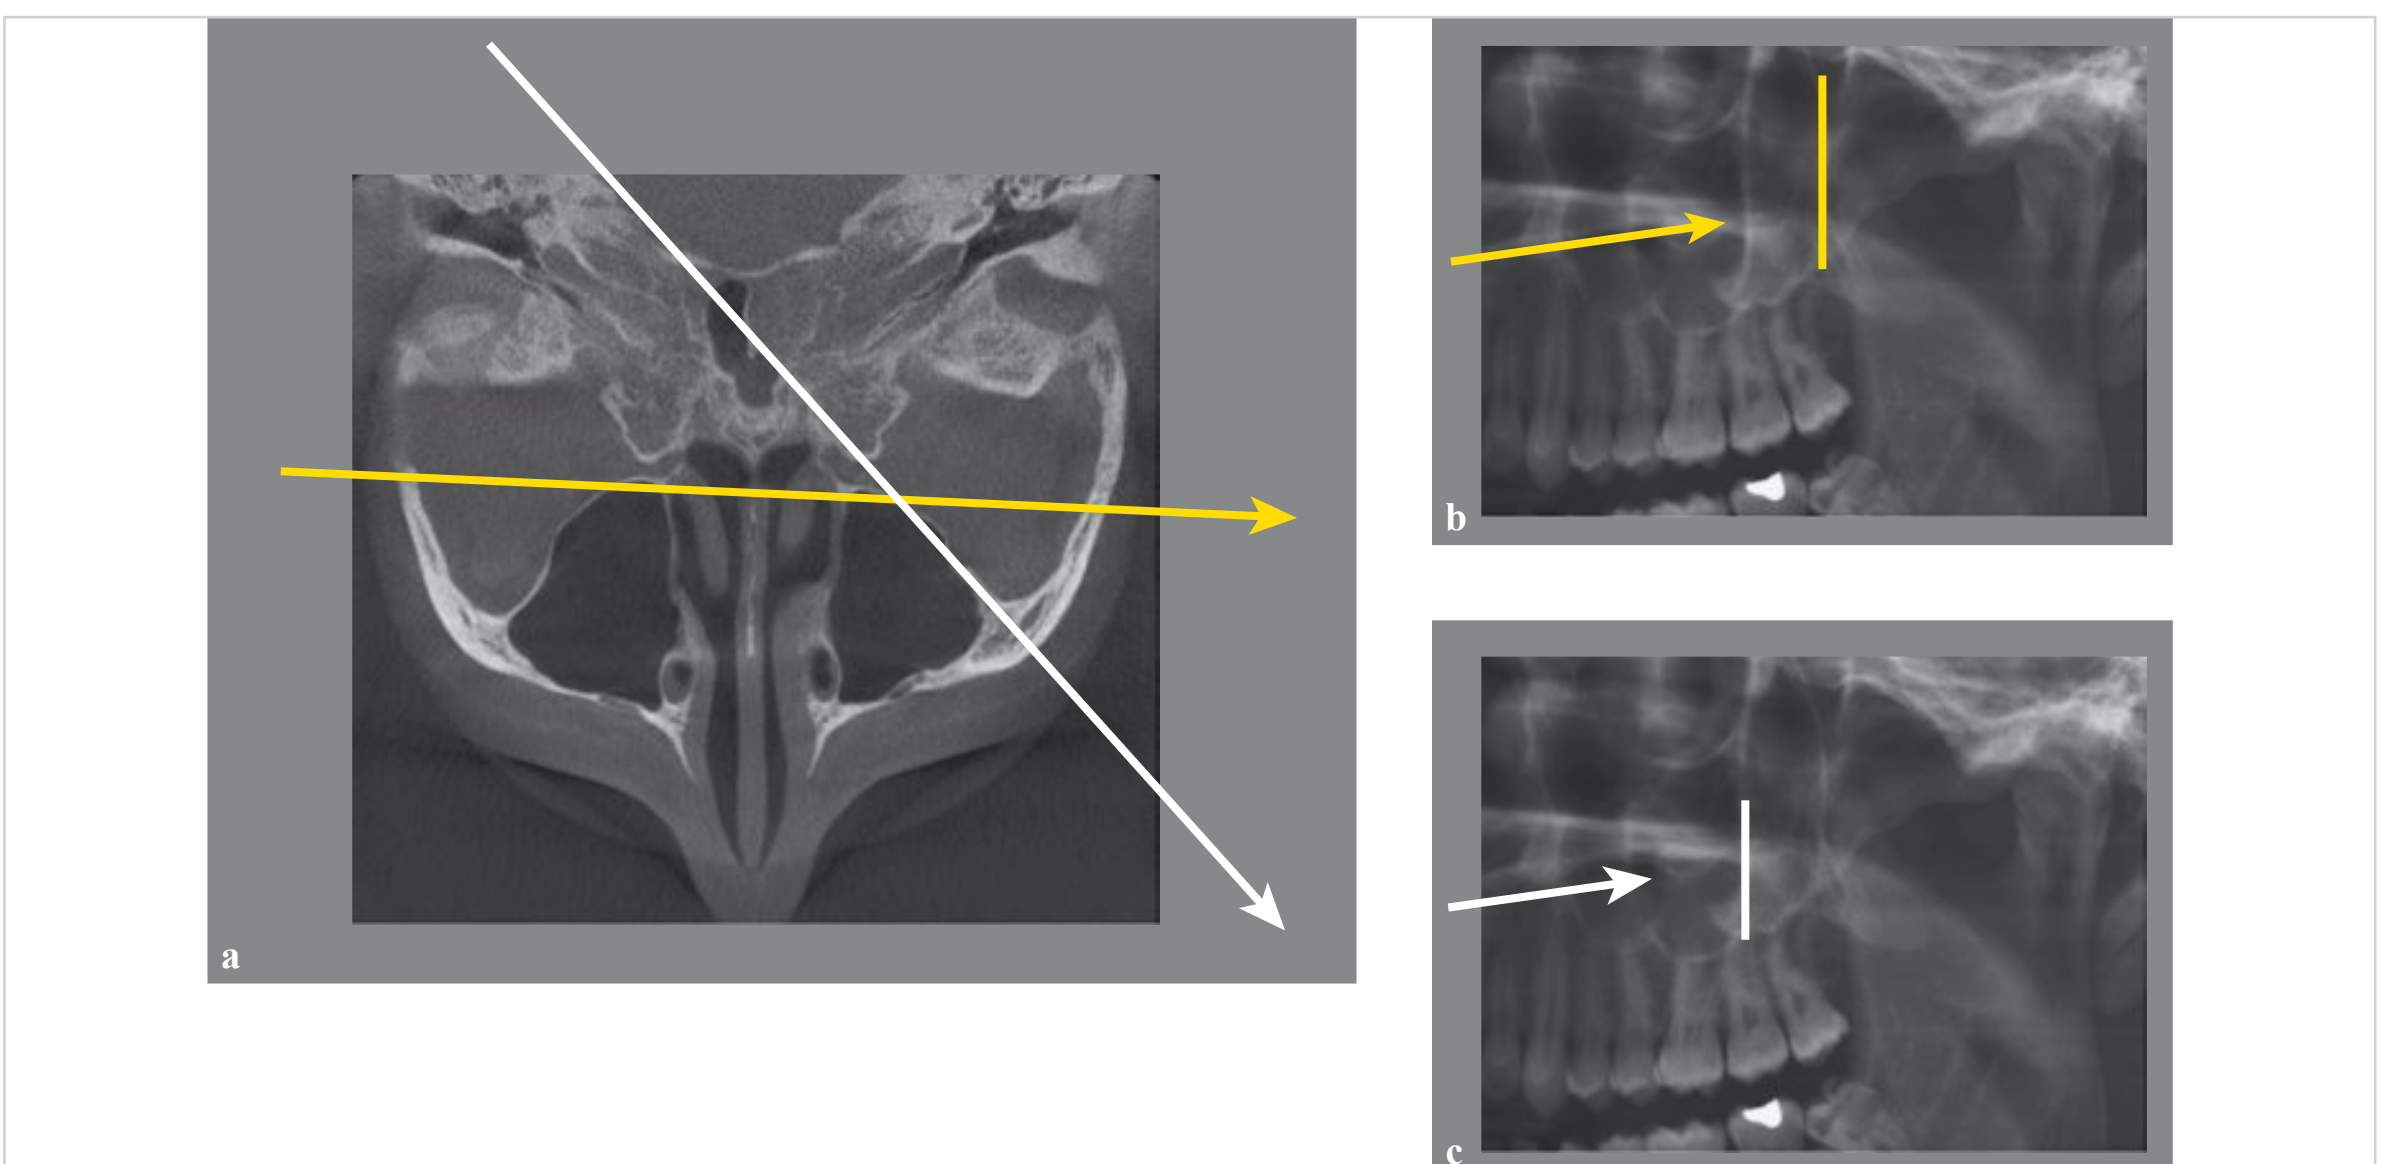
Visualization of the posterior and lateral walls of the maxillary sinuses by panoramic radiography. First, the posterior wall of the maxillary sinus (yellow) was visualized as a summation effect. Then, a tangential projection along the lateral wall of the maxillary sinus showed a second vertical line (white).
